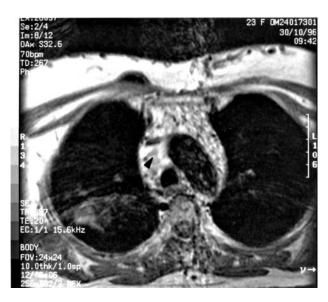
Coronal section, T1 weighted, magnetic resonance image showing organized thrombus (arrow) occluding SVC
